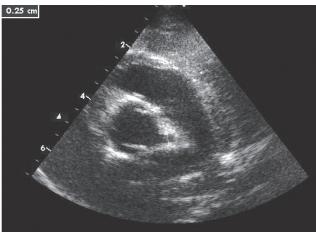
Repeated echocardiogram 6 months after onset of disease revealed ectasia of left main coronary artery, measured 2.5 mm in diameter
